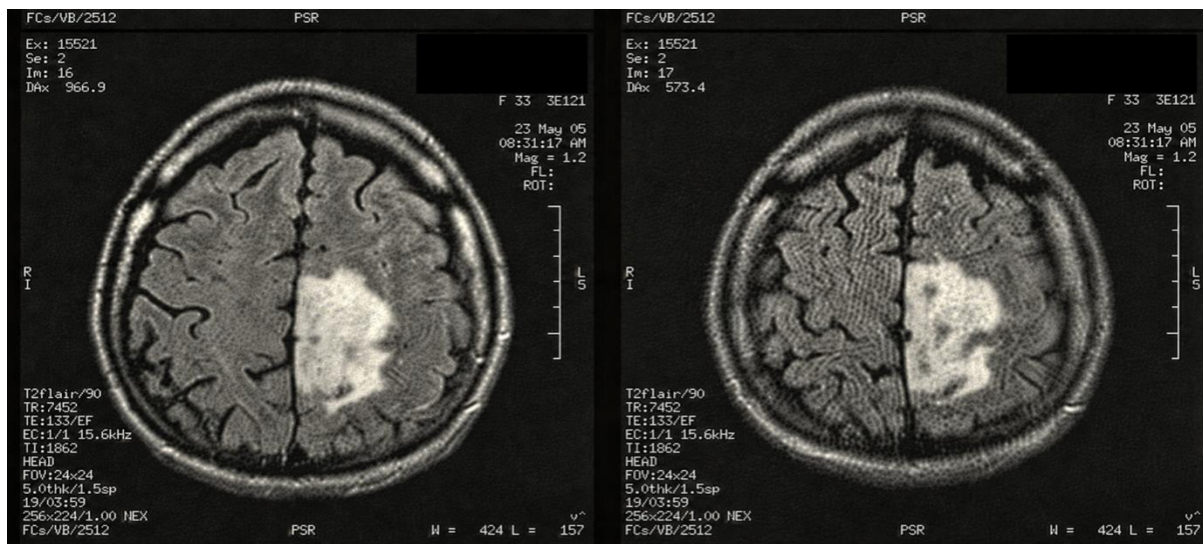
MRI sections of the brain tumor are acquired at different levels at the time of diagnosis (23 May, 2005).
